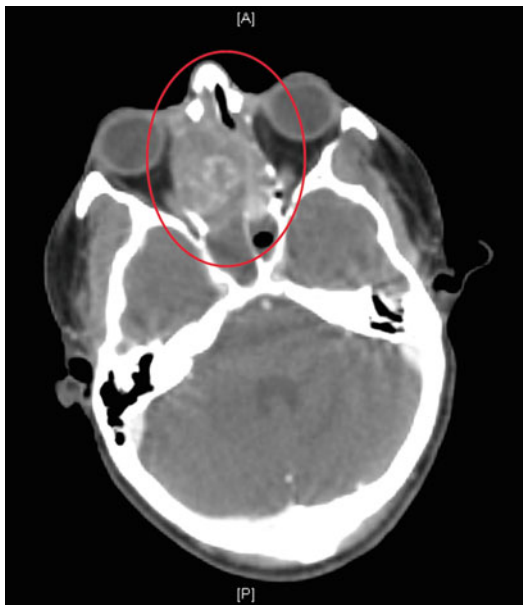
Contrast-enhanced CT of paranasal sinuses axial image showing a heterogeneously enhancing lesion (oval) involving the ethmoids with erosion of the nasal septum and medial wall of right orbit
